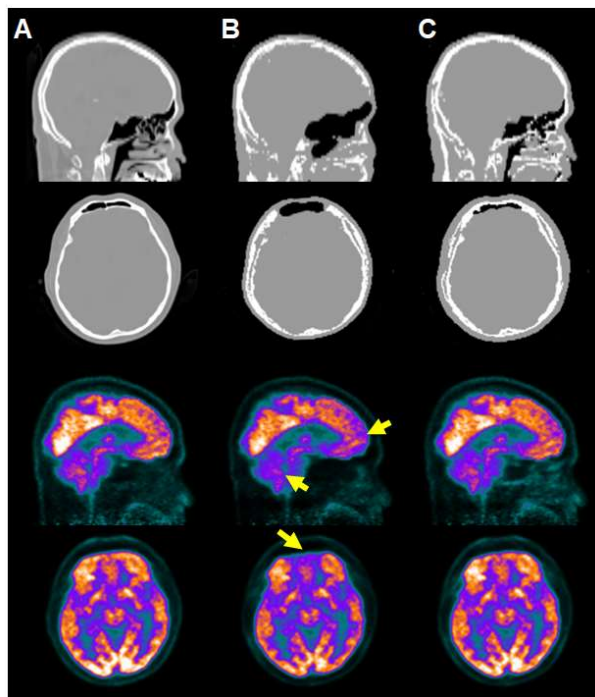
Attenuation maps and $[^{18}\text{F}]\text{FDG}$ PET images corrected using them. (A) CT, (B) $\text{MR-AC}_{\text{mMR}}$ using mMR software version VB20P, (C) $\text{MR-AC}_{\text{level}}$.
